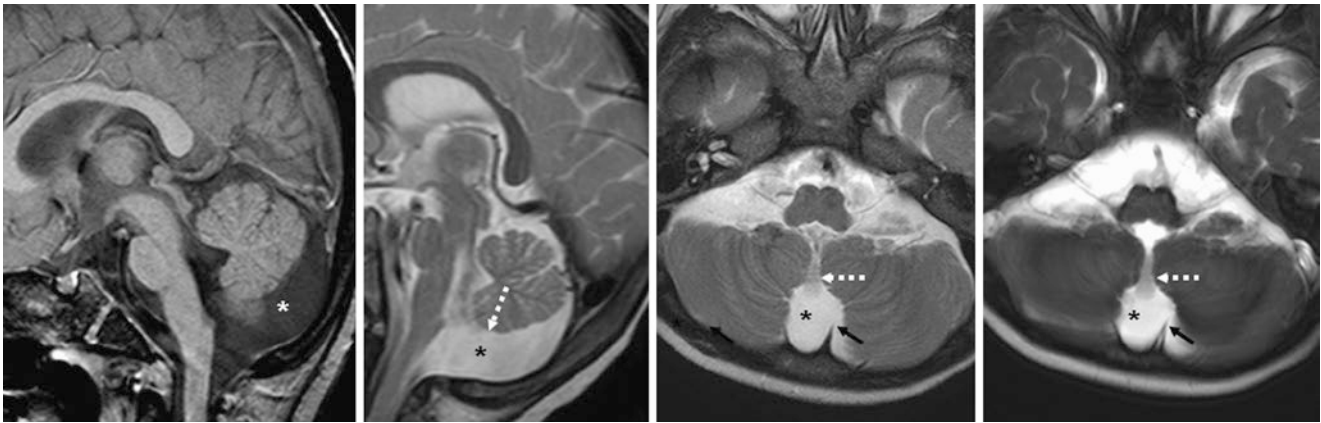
A 2 year old was found to have a small, cystic dilatation (*) posteroinferior to the cerebellar midline and vermis with a slightly enlarged posterior fossa. The cyst is traversed by the falx (arrows) on sagittal T1WI (left), T2WI (left middle), axial thin 2-mm T2WI (right middle), and balanced echo T2WI (right) 3 T MR images. The
